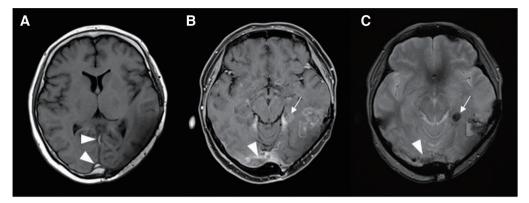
On Day 8, T1-weighted imaging revealed hyper-intensities in the straight sinus and superior sagittal sinus (arrowheads), suggesting the presence of a thrombus (A). Gadolinium-enhanced MRI (B) and T2*-weighted imaging (C) revealed a neoplastic lesion on the left cerebellar tent, indicating a new metastasis (arrows), and findings suggestive of tumor invasion from the right transverse sinus into the confluence of the sinus (arrowheads).
